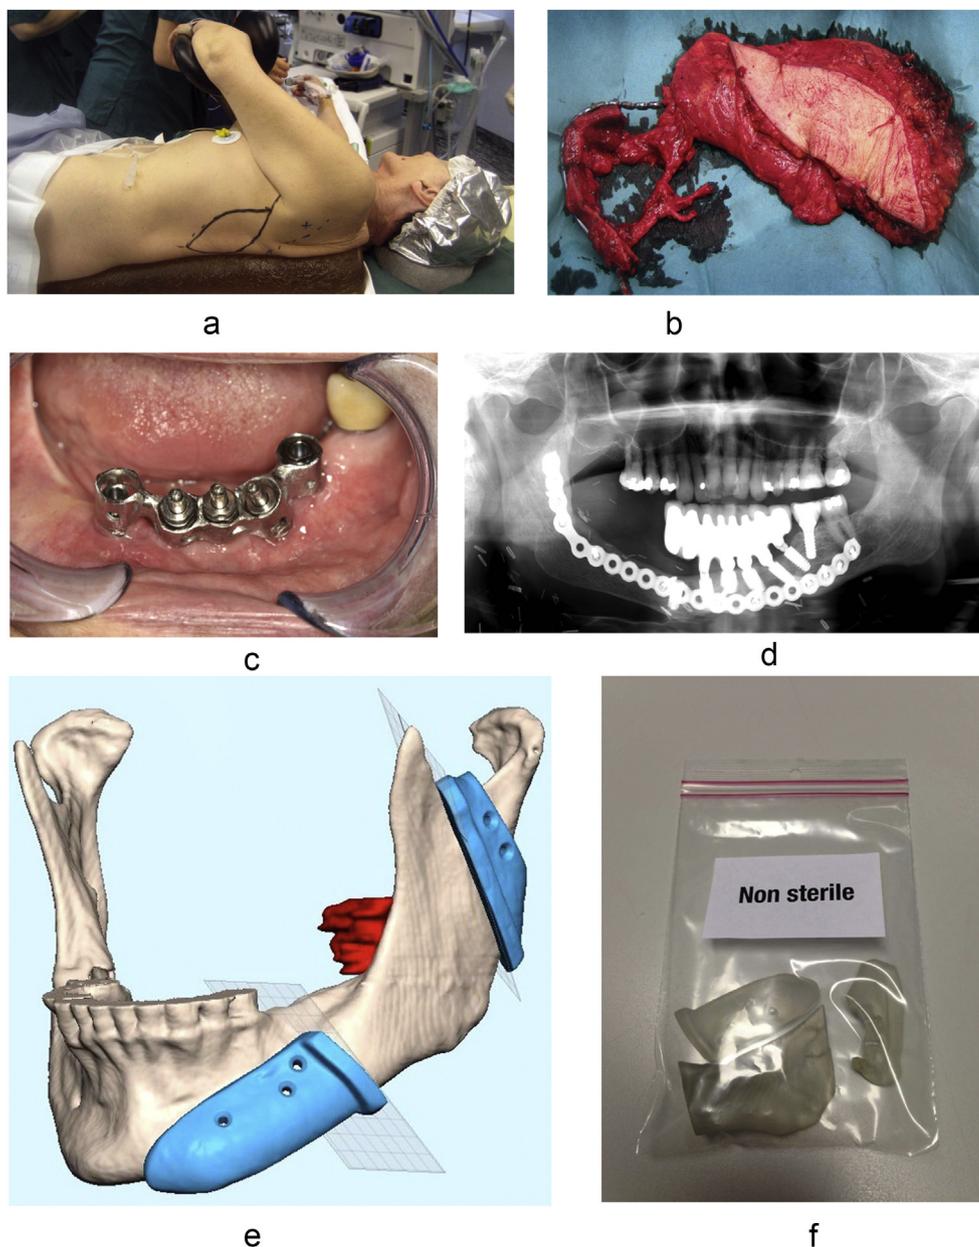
a. Positioning of the patient for enabling a two-team approach, b. The chimeric scapular flap with osteotomies. One osteotomy in the separate bone based on the marginal branch of the serratus pedicle and one in the separate bone based on the circumflex scapular vessels; both pieces also osteotomized in the middle, producing a four-piece bone. The flap also includes the latissimus muscle with the circumflex scapular, subscapular, thoracodorsal and marginal branch of the serratus vessels, c. Orthopantomography of a patient with dental implants in the scapular flap, d. Clinical oral image of a dental reconstruction based on the implants, e. 3D planning of mandibular resection and planned guides for osteotomies, f. Manufactured guides for osteotomies in the mandible and the scapula.
